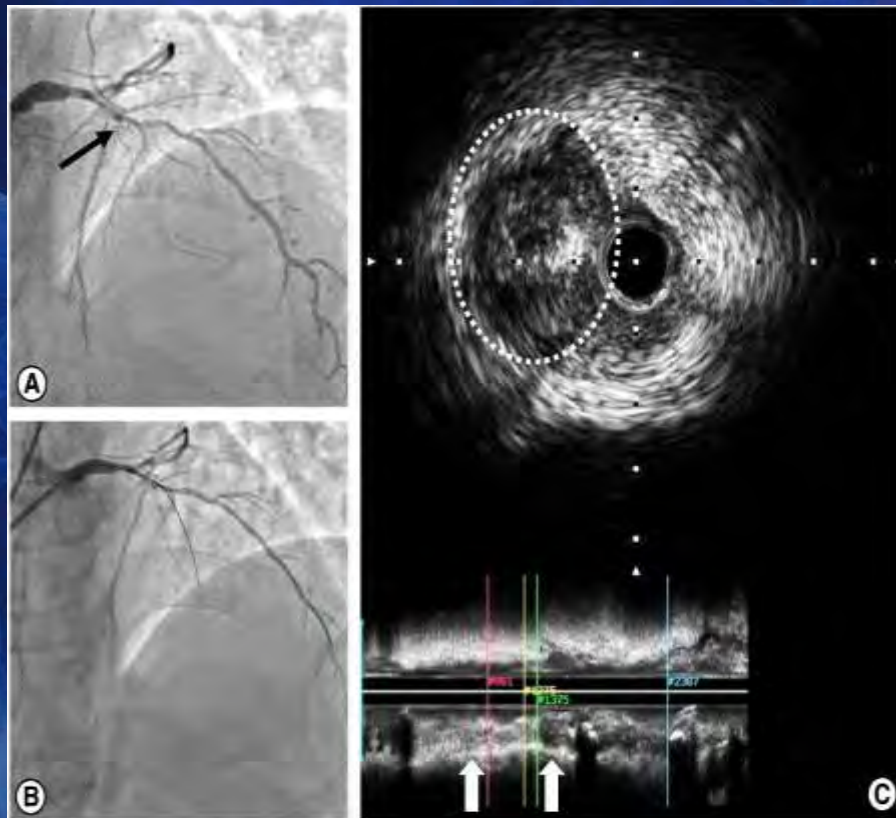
Intravascular ultrasound images of sub-intimal passage. A. A left anterior descending artery was totally occluded just distal to the diagonal branch and the stump was hardly recognizable (black arrow). B. A guidewire seemed to cross the lesion. Howe...
